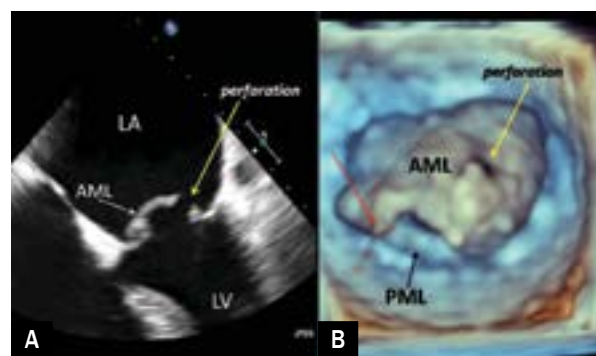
Mitral valve infective endocarditis in patient with end-stage renal disease: large perforation of anterior mitral leaflet (AML) (yellow arrow), a broken primary tendinous chord (red arrow); A. Two-dimensional (2D) transoesophageal echocardiography (TEE); B. Three-dimensional (3D) TEE; LA – left atrium, LV – left ventricle, PML – posterior mitral leaflet
